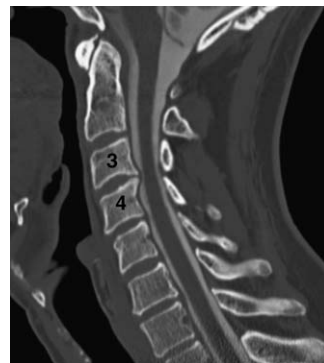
Sagittal CT reconstruction of the cervical spine confirms central stenosis from end plate osteophytes with a notable decrease in the space available for the spinal cord at the C3-4 level.
